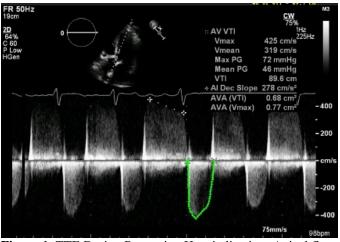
TTE During Presenting Hospitalization: Apical fivechamber view via transthoracic echocardiogram reveals severely elevated pressure gradient and velocity across the valve.
